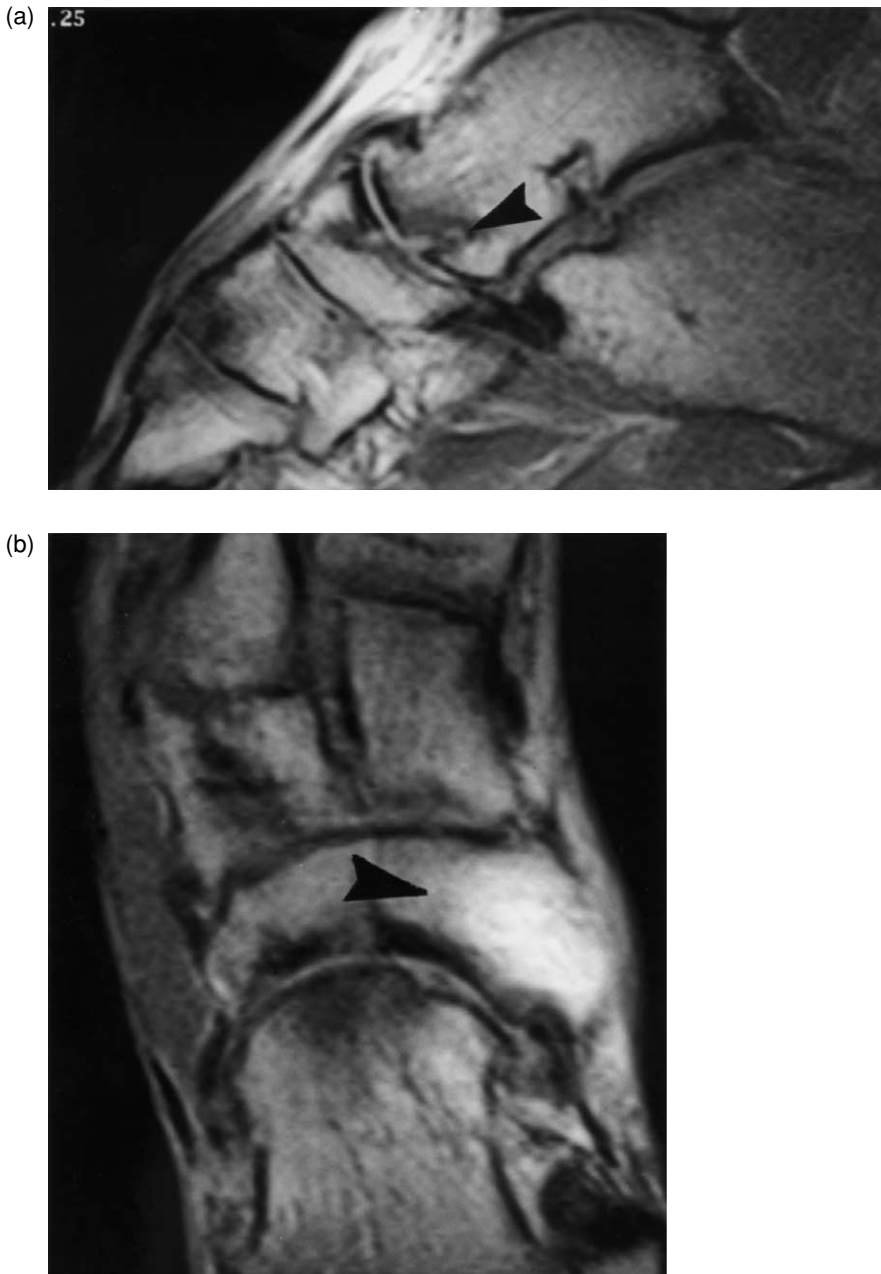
(a) MR imaging of the foot 10 months after the injury. Note the increased subchondral sclerosis (arrow). (b) Bone marrow edema (arrow) 10 months after the injury.
